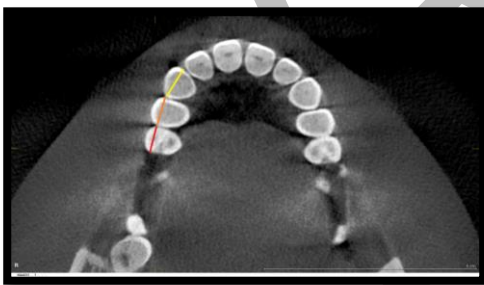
measurement from CBCT using the distance tool
